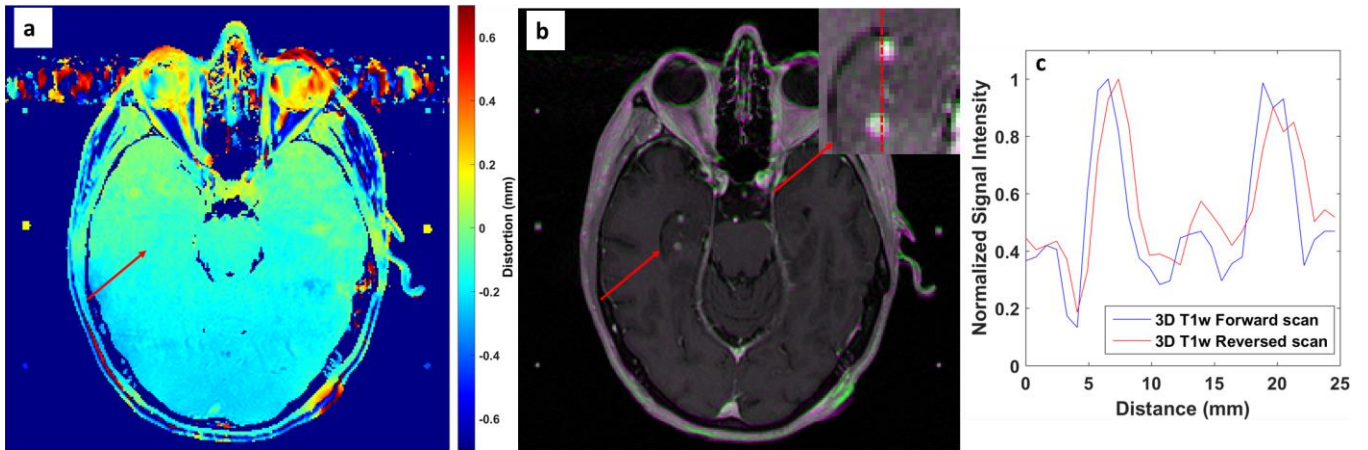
(a) Field mapping derived distortion map corresponding to an axial slice with two brain metastases (metastases #4 and 5 in Table 6-3). (b) Fused forward (A-P) and reversed (P-A) polarity MR images using the clinically employed MR protocol for SRS treatment planning. Corresponding pixels with different values are depicted in color (green and purple for higher values in forward and reversed images, respectively). The area of the two metastases is depicted magnified in the insert. The red arrow points to the area of the two metastases. (c) Normalized pixel intensity profiles for the two images along the red dashed line that runs parallel to the y-axis.
